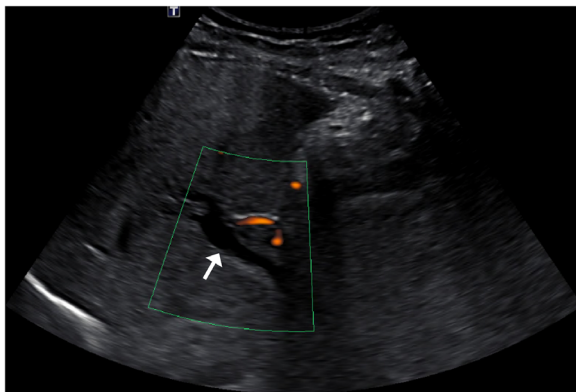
Power Doppler ultrasound image through the main portal vein (white arrow) demonstrating absence of flow consistent with thrombosis
